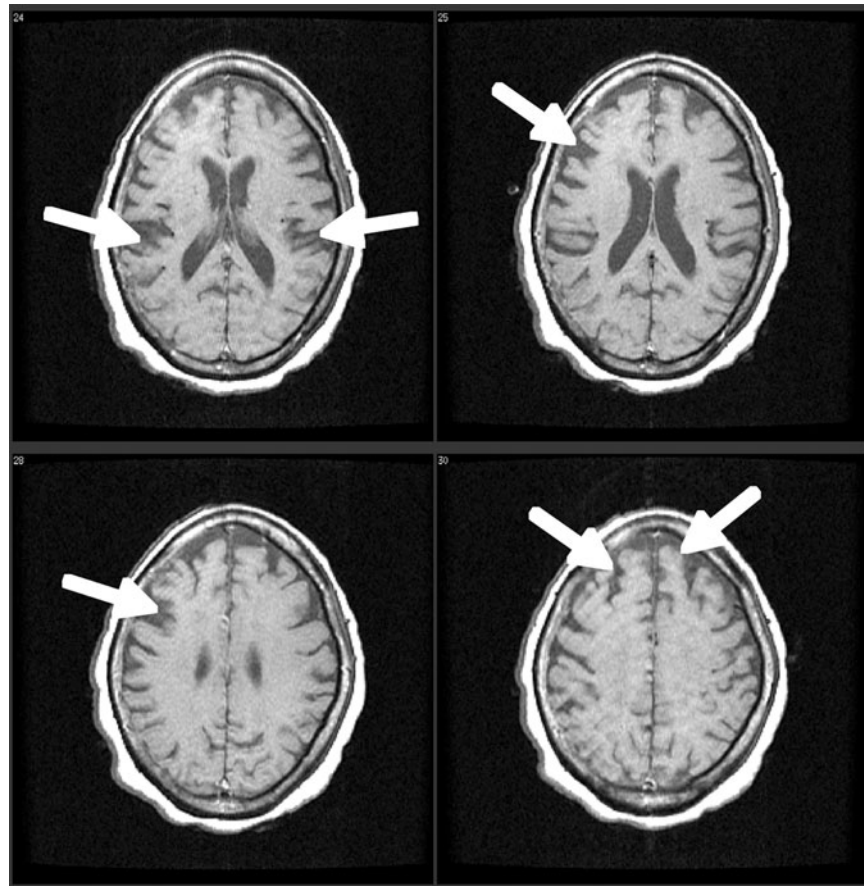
FLAIR images of patient with HAM/TSP depicting diffuse and confluent lesions around ventricles and along the pyramidal tract. Arrows highlight areas of decrease in brain parenchyma.
